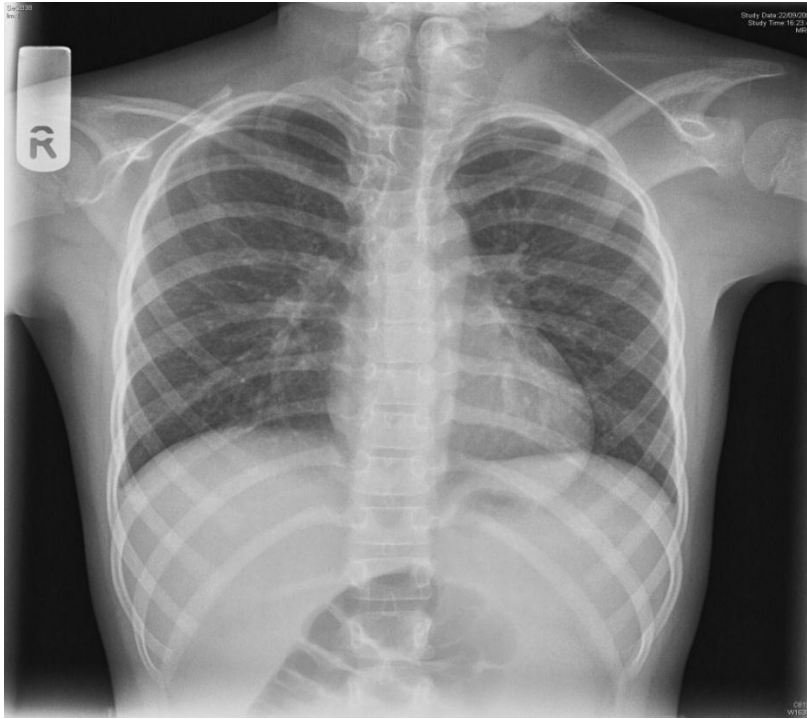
Post-op X-ray showing Rigault's grade-1 at follow-up following modified Woodward's procedure
